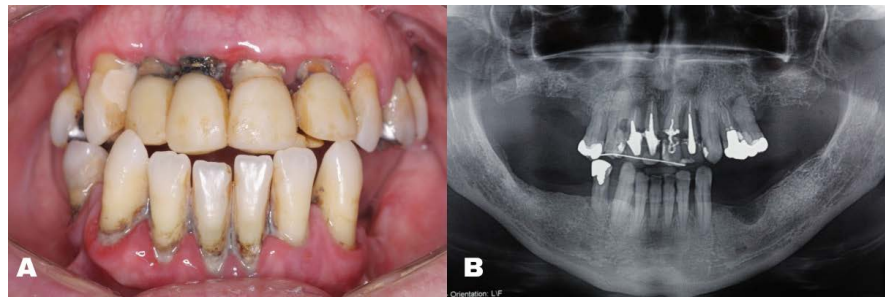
A, frontal intraoral view, showing Angle's Class III occlusal pattern. B, initial panoramic radiography.
